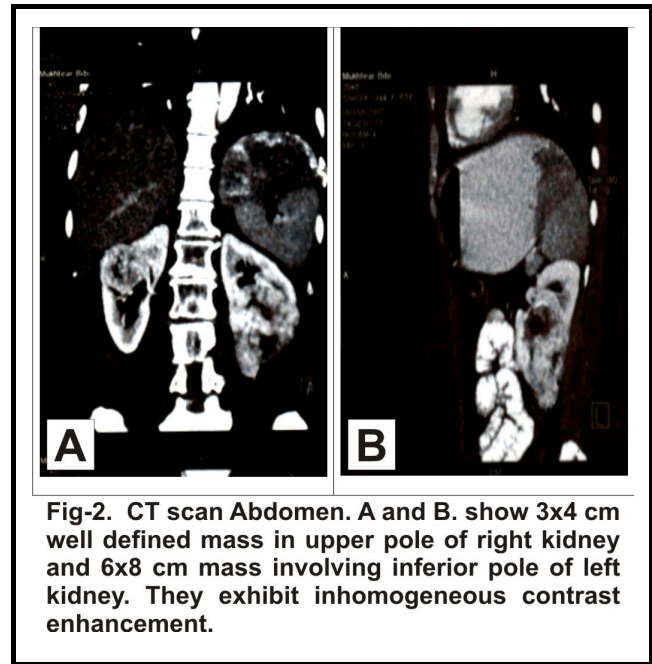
CT scan Abdomen. A and B. show 3x4 cm well defined mass in upper pole of right kidney and 6x8 cm mass involving inferior pole of left kidney. They exhibit inhomogeneous contrast enhancement.
